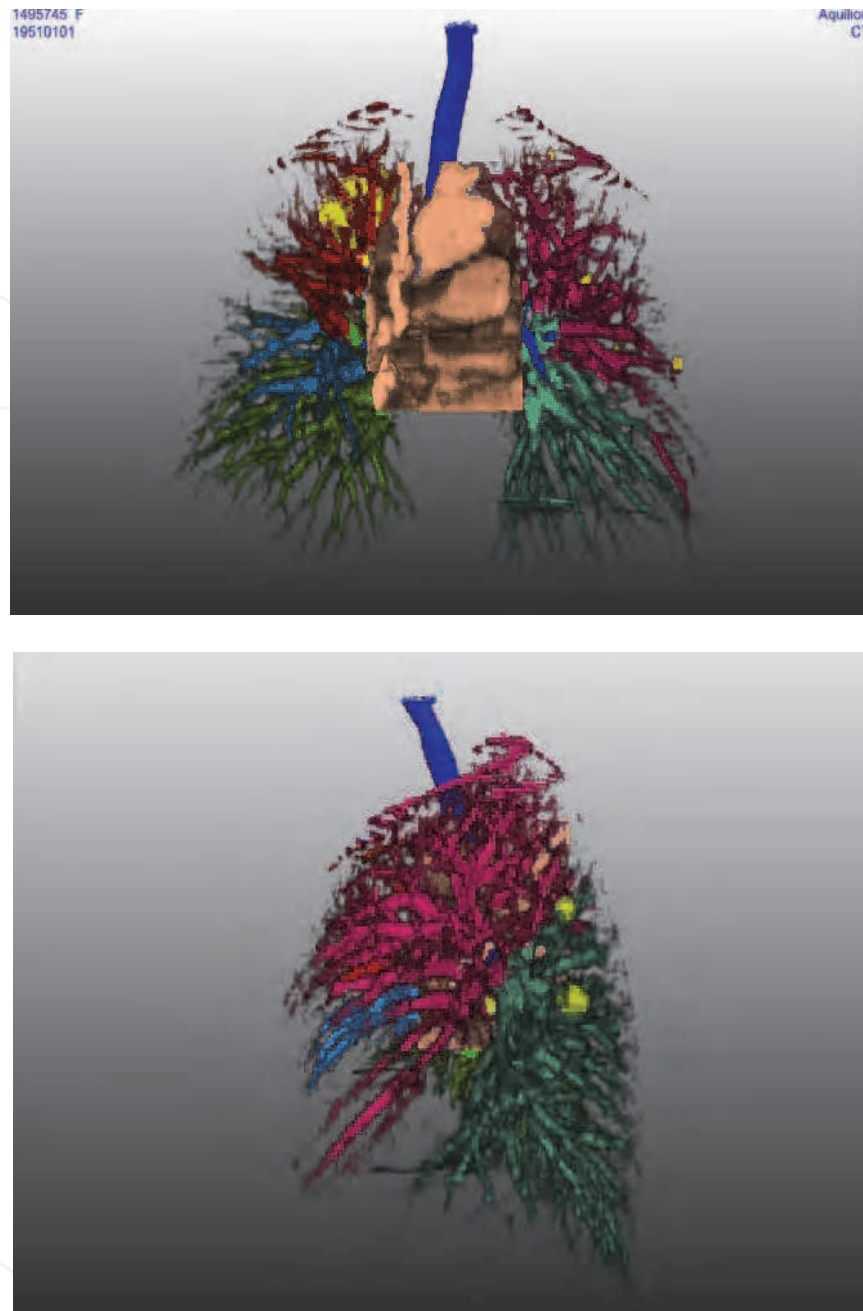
Animated 3-D reconstruction of the axial CT images (3.1). Ventral (left) and left-lateral (right) view. The lobes of the lungs are coloured selectively, the bronchial tree is blue, lung metastases are coloured yellow.
